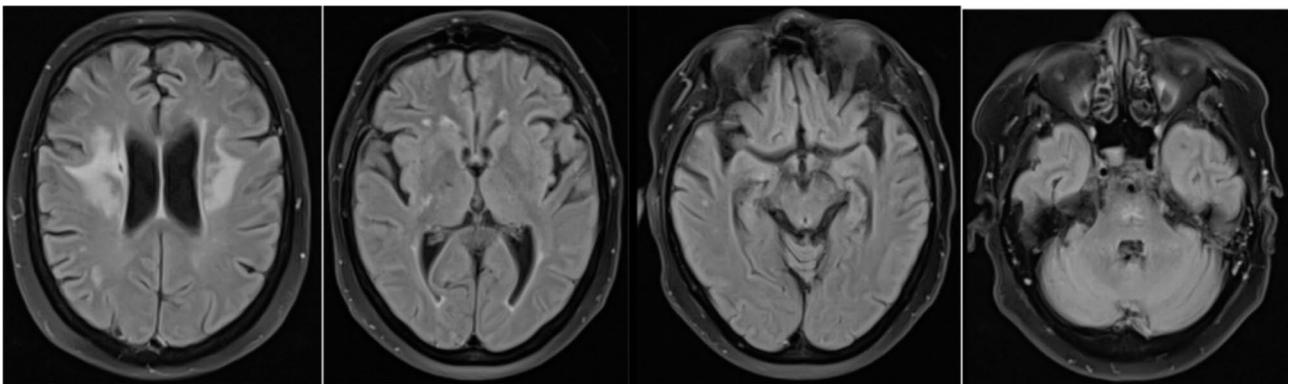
MRI (T2/FLAIR) after 3.5 months showing progressive resolution
